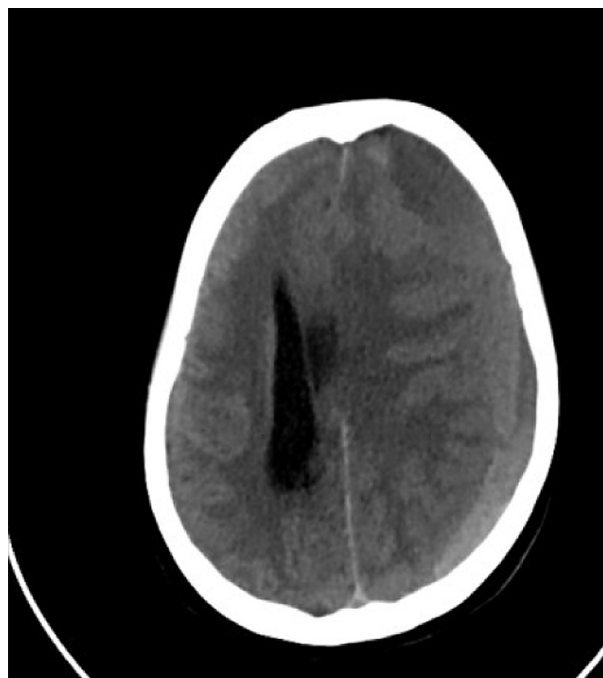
CT (plain) image of a case of CSDH.
